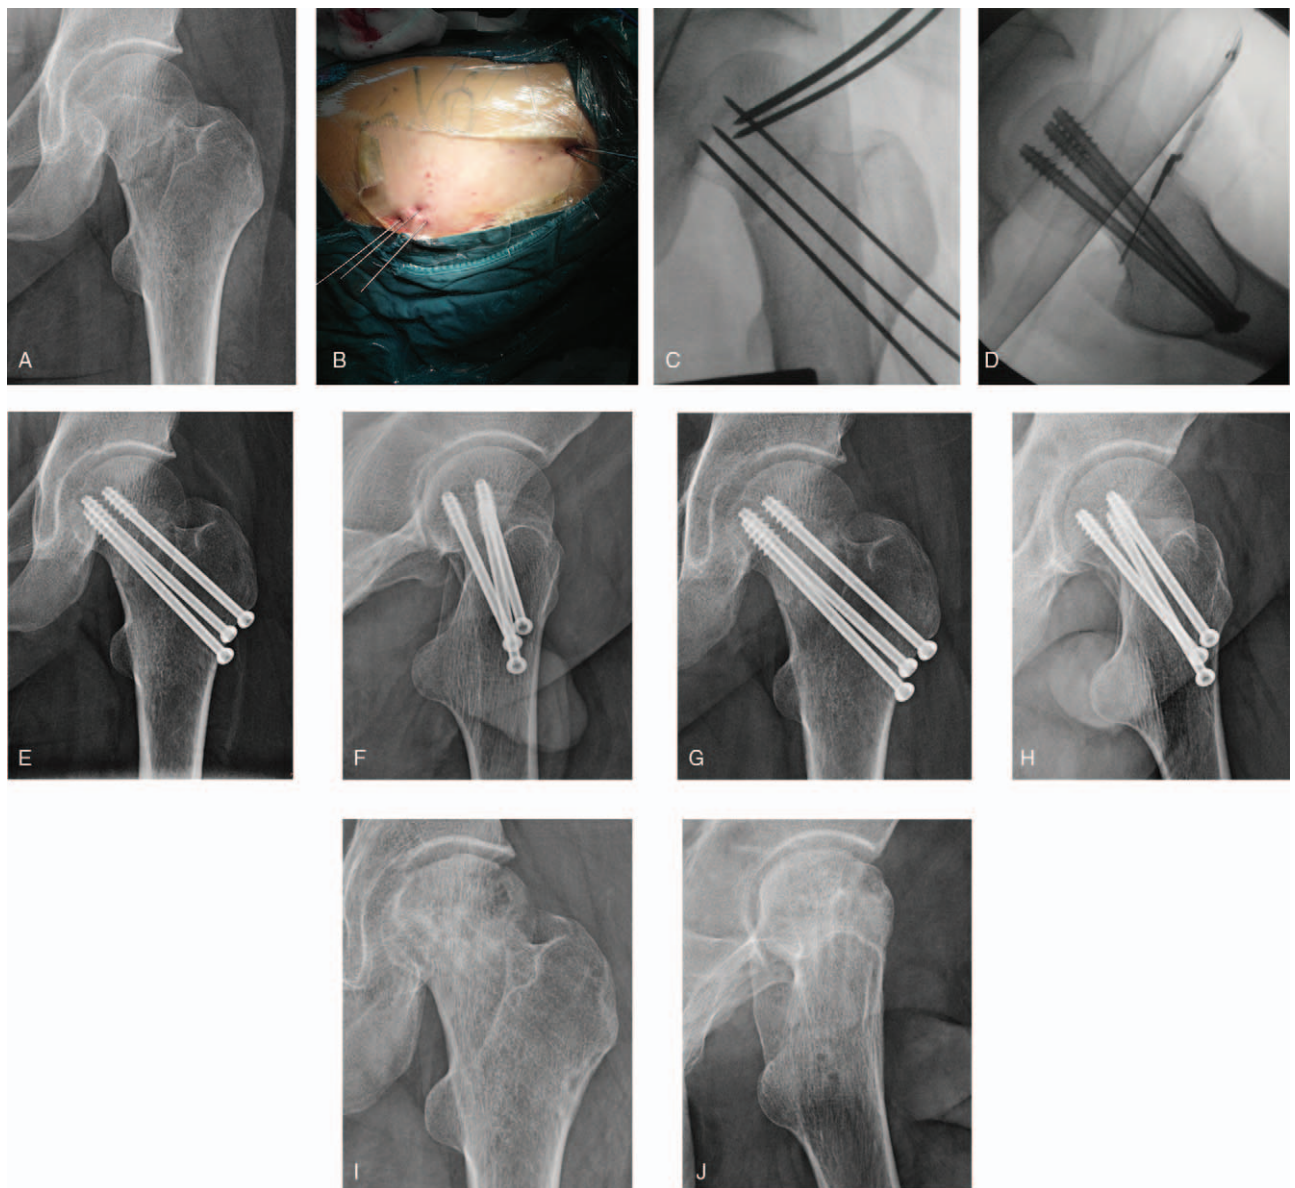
A 35-year-old male suffered a left femoral neck fracture from a traffic accident. (A)The anteroposterior radiograph; (B) The entity figure after inserting the Kirschner wire; (C) Percutaneous reduction by leverage; (D) Implant 3 hollow screws; (E) and (F)Two days after surgery, the anteroposterior radiograph and the lateral radiograph, respectively; (G) and (H) Three months after surgery, the fracture line had blurred in the anteroposterior radiograph and the lateral radiograph, respectively; (I) and (J)The fracture had healed well after removal of the internal fixation in the anteroposterior radiograph and the lateral radiograph, respectively.
